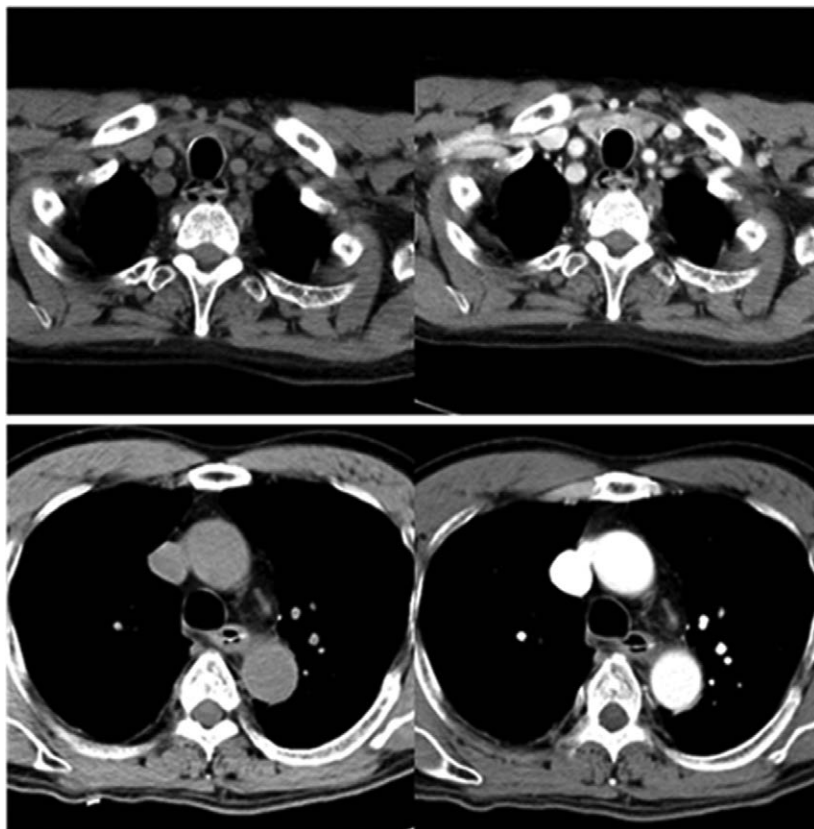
Without contrast media, fish bones can be detected by adjusting the computed tomography windowing.
